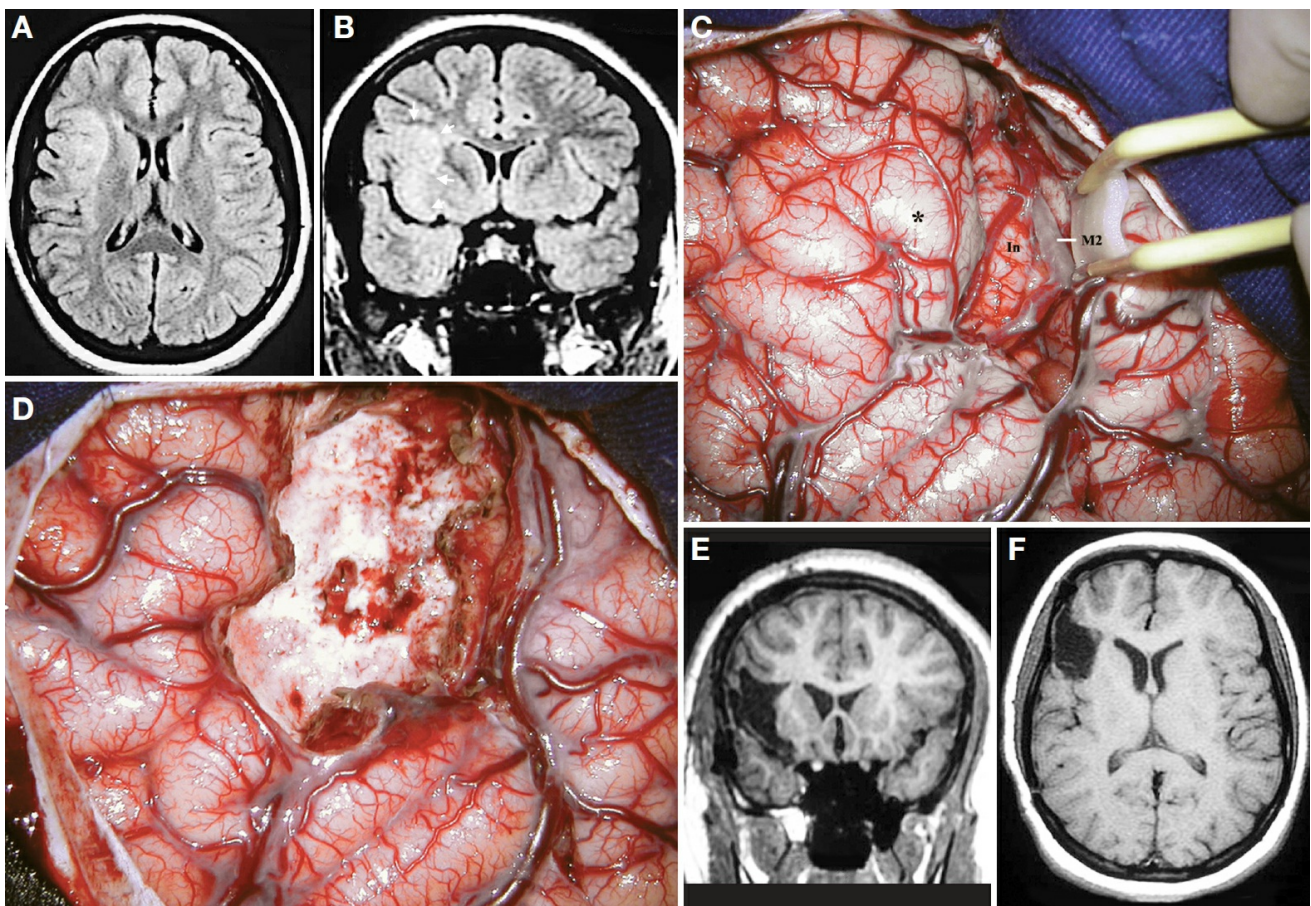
A, axial MRI scan. B, coronal MRI scan at the anterior part of the insula. Note that the superolateral insular cleft on the right side is lacking. Arrows indicate the [cortical dysplasia](#). C, surgical exposure after right pterional craniotomy, dural opening, and sylvian fissure splitting. M2, insular segment of the MCA; In, insula. Asterisk, cortical dysplasia. D, intraoperative photograph after the removal of the cortical dysplasia. E, postoperative coronal MRI scan showing the resection of the cortical dysplasia. F, postoperative axial MRI scan. (Images courtesy of AL Rhoton, Jr.)
